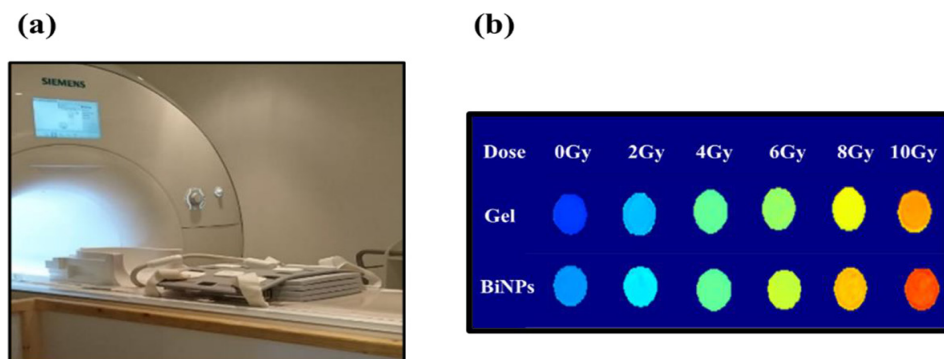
MRI imaging and corresponding R_2 map of MAGICA gel dosimeters. (a) Representative view of 1.5 T MRI imaging. (b) R_2 map of pure MAGICA gel and gels containing 0.1 mM BiNPs, irradiated with 6 MV photon beam at doses of 0–10 Gy. (MRI: Magnetic Resonance Imaging)
